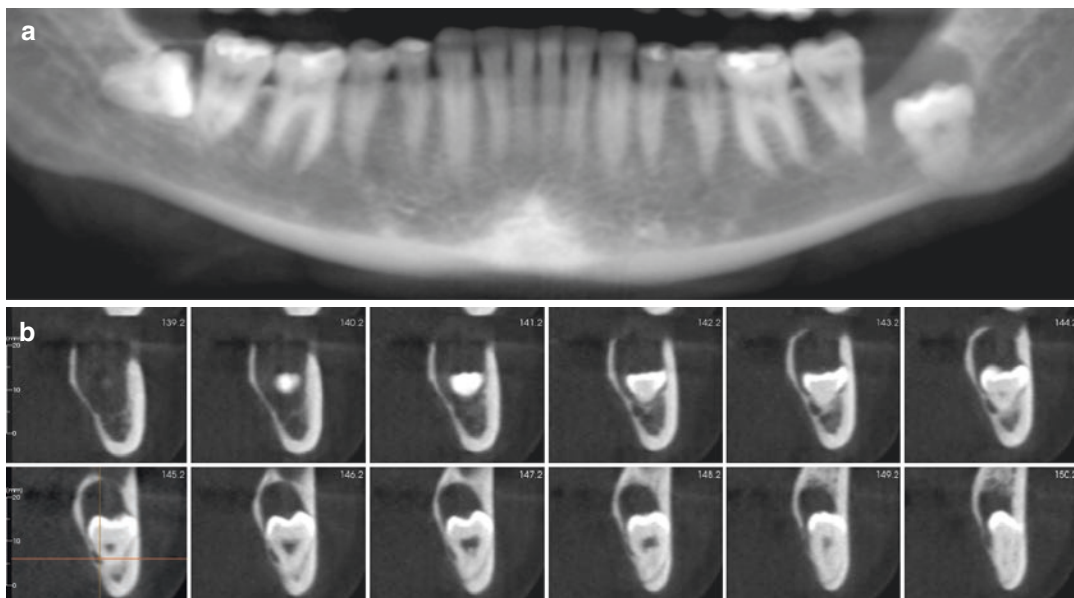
Reformatted panoramic CBCT image of a 22-year-old patient showing a widening of the follicular space of a distoangular, partially bony impacted mandibular right third molar
